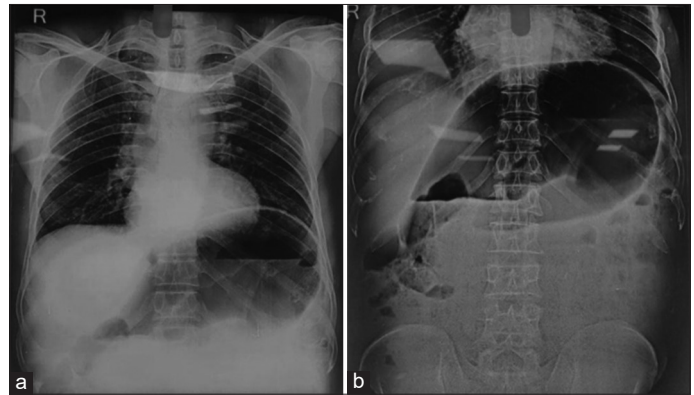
(a) Plain Chest X-ray PA view showing dilated bowel loop and (b) Plain erect abdominal X-ray showing classical “COFFEE BEAN SIGN”
